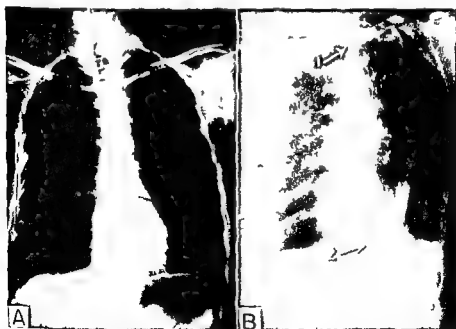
Roentgen film of a patient age 22 who was operated upon for cicatricial obstruction of almost the entire esophagus resulting from ingestion of lye with suicidal intent *A* Preoperative esophagogram (Note small pharyngo-esophageal diverticulum already present) *B* Postoperative film following subtotal esophagectomy and esophagogastric anastomosis 1 anastomosis 2 pylorus
